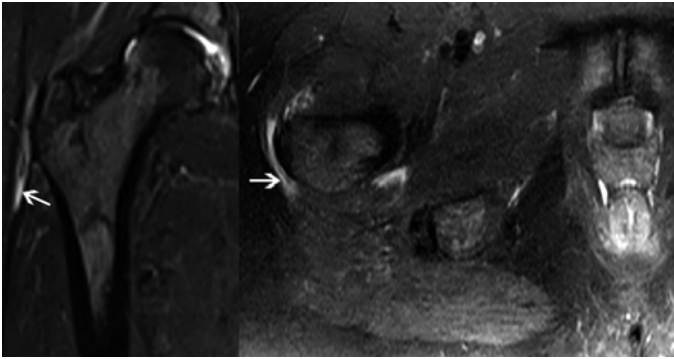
Coronal and axial T2-weighted MR through the pelvis show increased fluid signal (*white arrows*) lateral to the greater trochanter, consistent with greater trochanteric bursitis.
